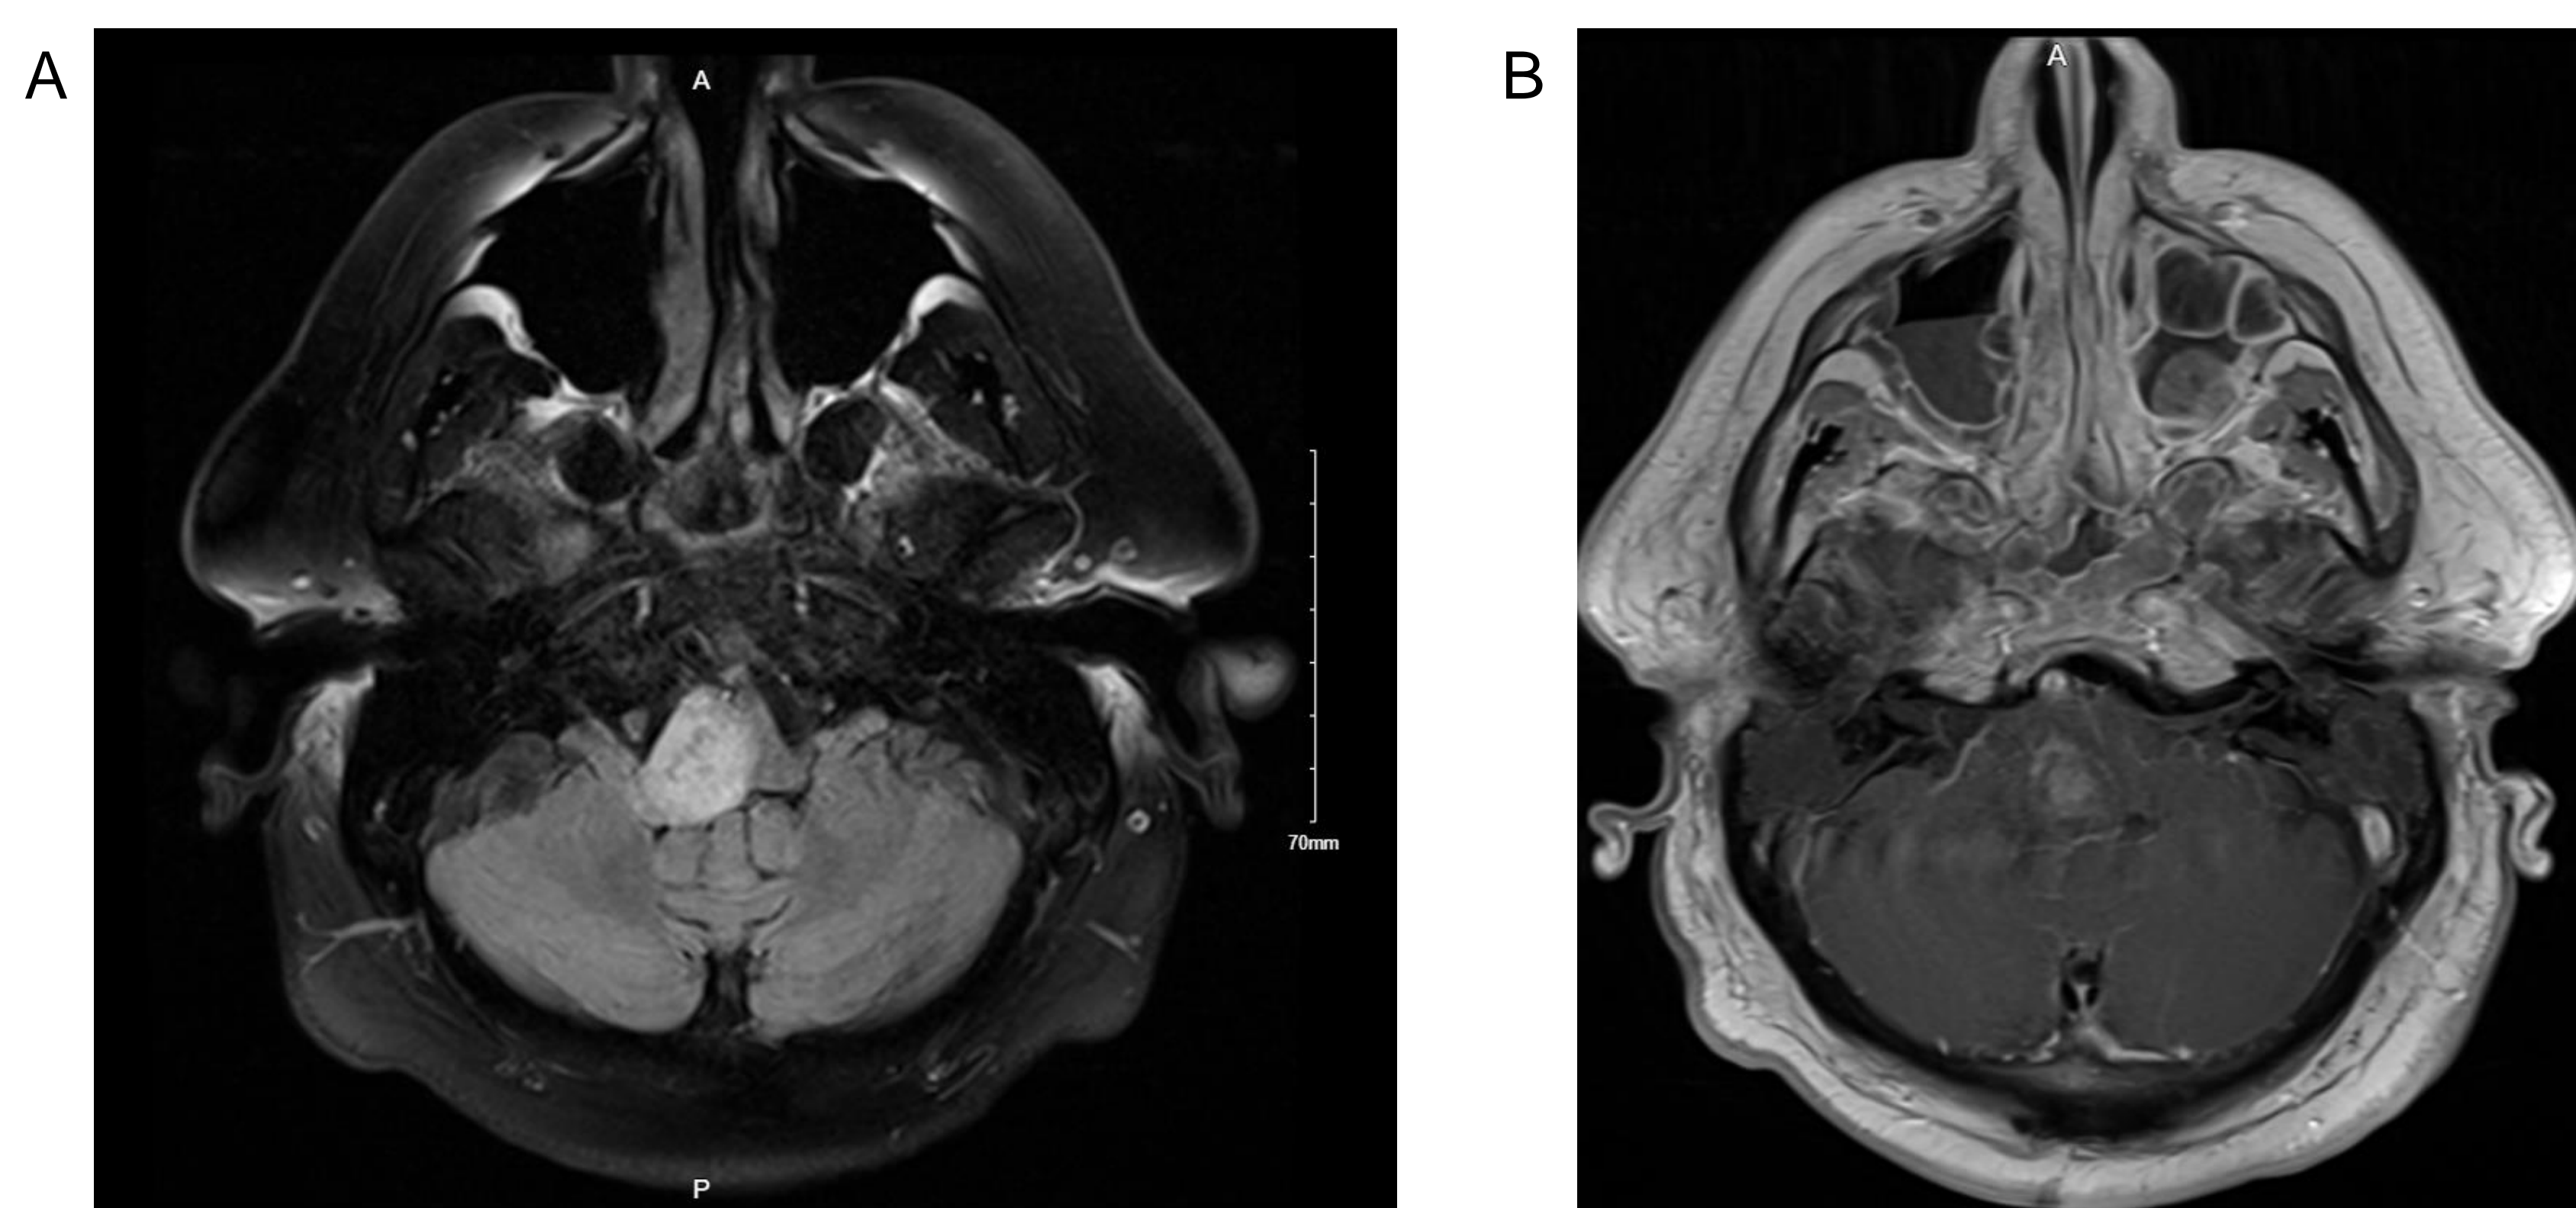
A) Pre-operative axial T2-weighted FLAIR and B) T1-weighted post-contrast sequences demonstrating a 2.5x2.2x3.2 lesion at the pontomedullary brainstem
